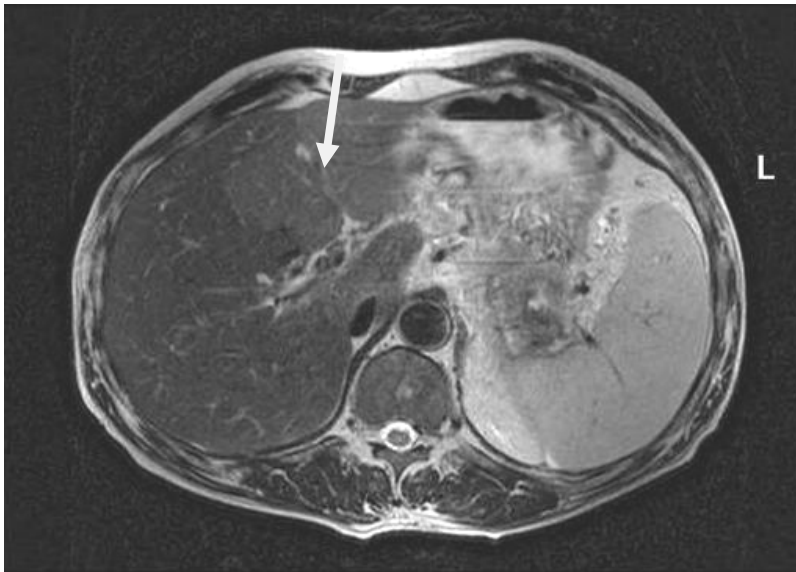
MRI of liver. T2-WI. Inflammation with more intensive signal (arrow) is defined in liver tissue. Acute hepatitis.
